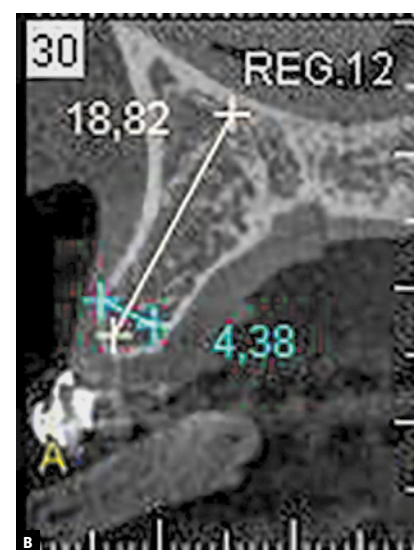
Cone-beam CT slices. Panoramic view shows interradicular distance between teeth #13 and #11 (A). Sagittal view shows anteroposterior and vertical bone thicknesses in region of missing tooth #12 (B).
